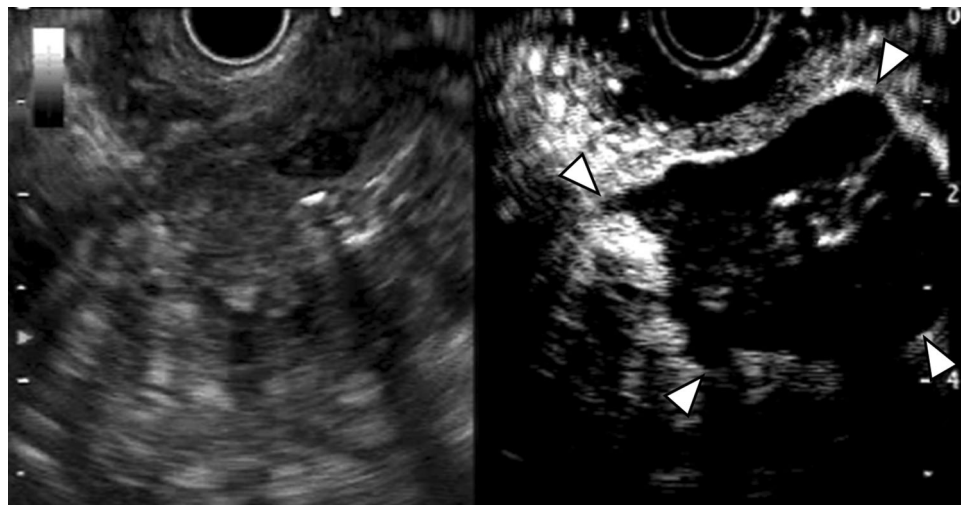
Transluminal drainage of walled-off necrosis (WON) under contrast-enhanced harmonic endoscopic ultrasonography (CH-EUS) guidance. a Under CH-EUS guidance, the WON was punctured using
